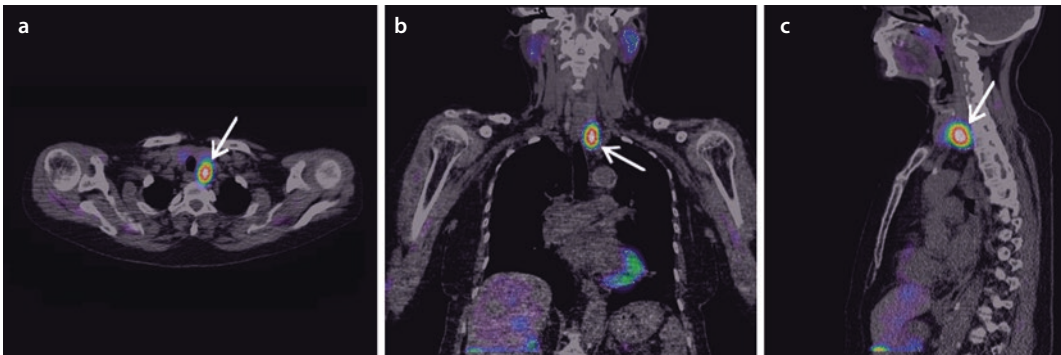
A fused ^{99m}Tc -MIBI SPECT/CT of a left inferior parathyroid adenoma (arrows)—axial a, transverse b, and sagittal c images
